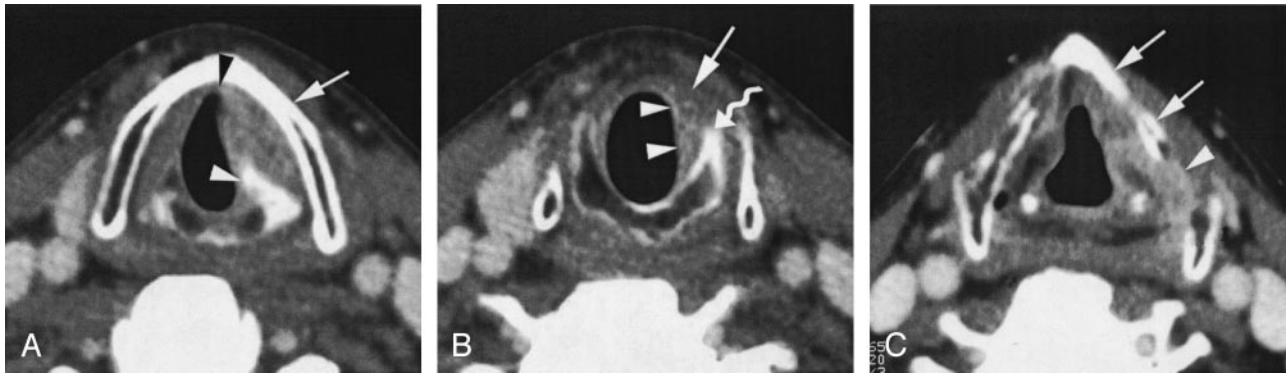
Axial contrast-enhanced CT-images in a 55-year-old male patient with a glottic cancer (T3N0).
